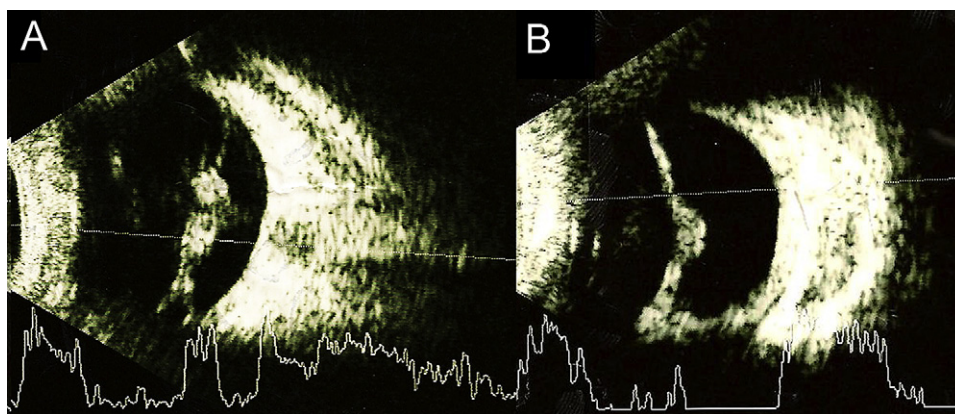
Ultrasonographs of the right (A) and left (B) eyes showing delayed-onset total retinal detachment at 4 months after photocoagulation and intravitreal ranibizumab injection.
